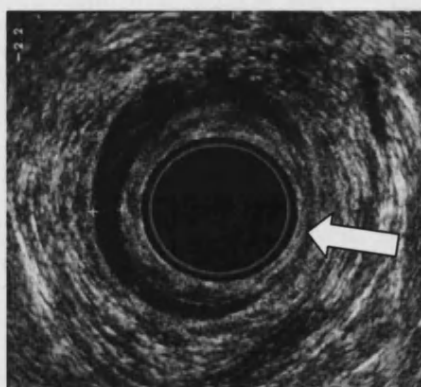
Endoanal ultrasound demonstrating the appearance of the internal anal sphincter (IAS) after lateral sphincterotomy for chronic anal fissure. The white arrow indicates the defect in the IAS.
